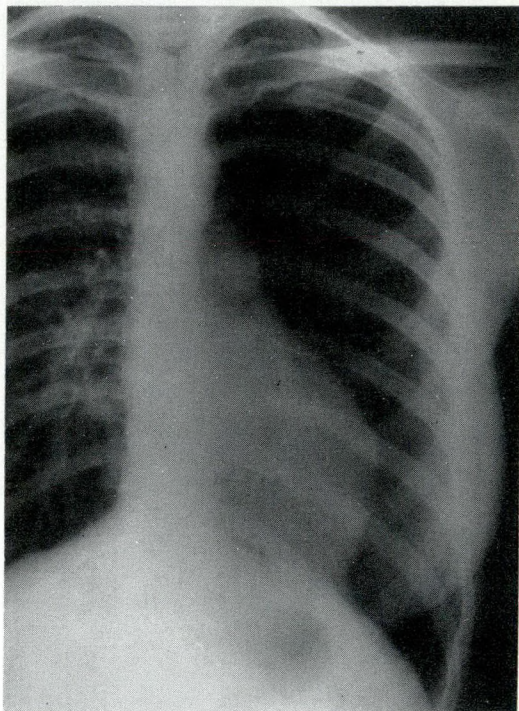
Preoperative chest roentgenogram showing prominence of the pulmonary artery segment and slight shift of the heart shadow to the left.
